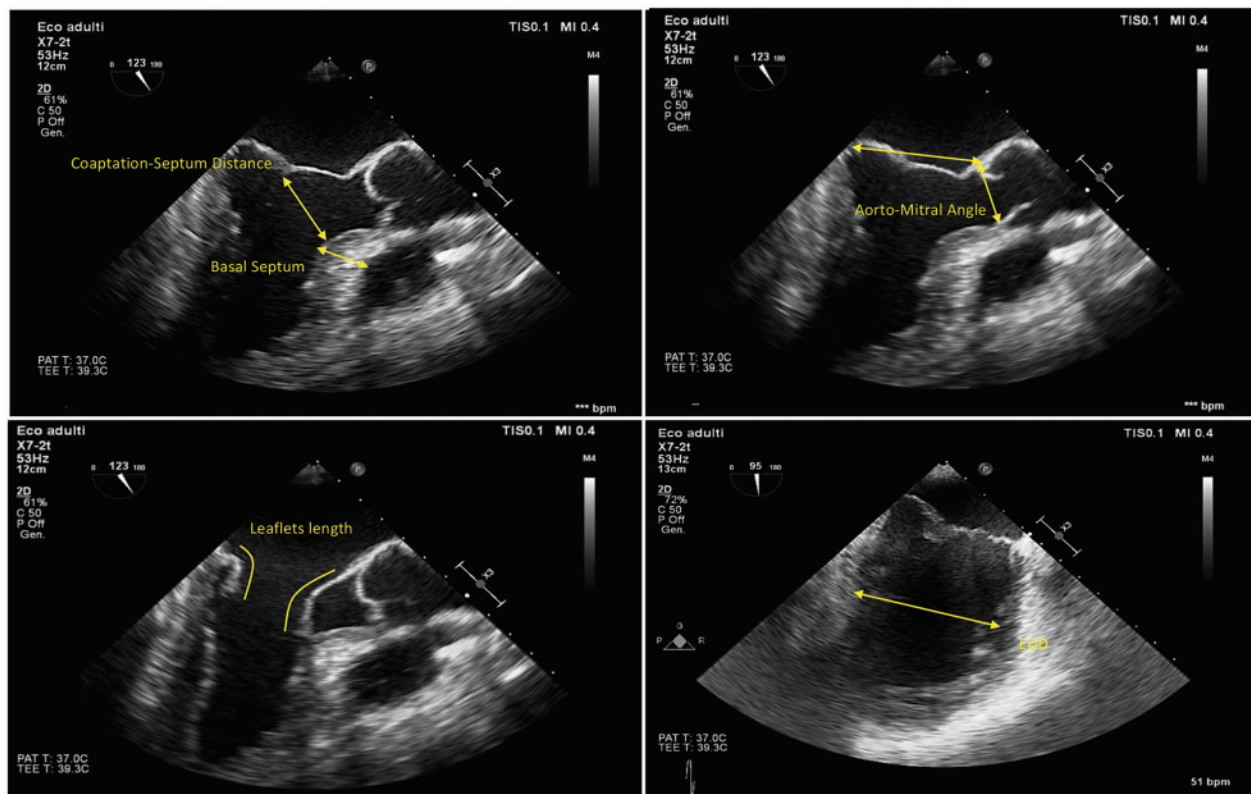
Transoesophageal echocardiographic views with the 6 parameters chosen as predictors of systolic anterior motion: coaptation-septum distance, basal septum, aortomitral angle, posterior leaflet length, anterior leaflet length and end-diastolic diameter.
